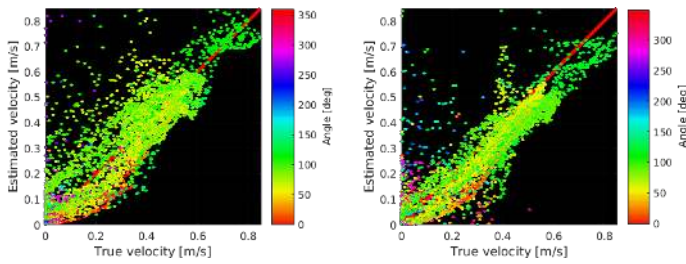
Scatter plots of true (CFD) velocities versus ultrasound estimations of velocity magnitudes at peak systole. Estimates from TO (left) and TO-DB (right) color encoded with estimated angle.
